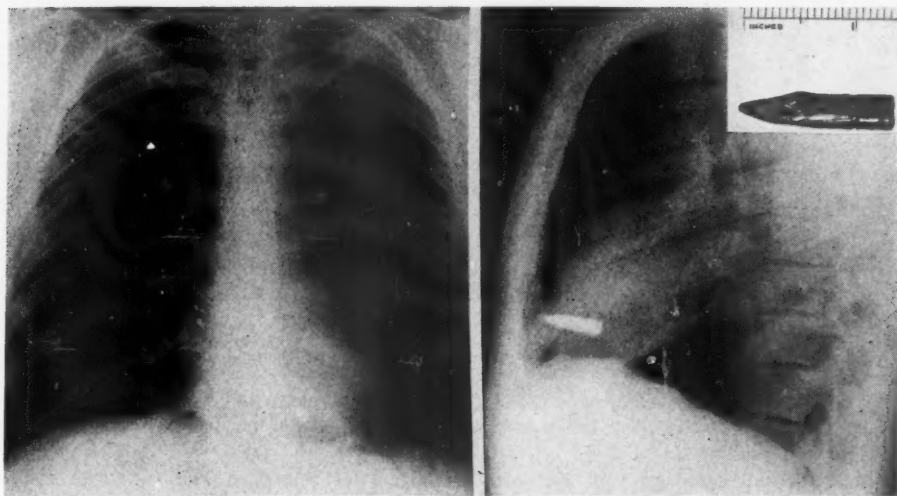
Case 14: Roentgenograms showing bullet (insert) imbedded in what subsequently proved to be the interventricular septum about 0.8 cm. below the surface of the myocardium. Injury occurred December 7, 1941. Bullet removed April 17, 1942.
